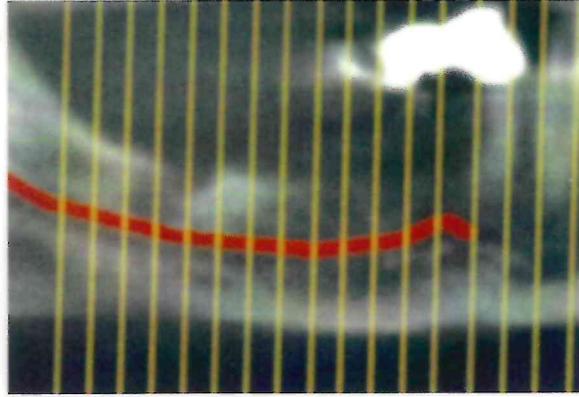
CT scan reveals that the inferior alveolar nerve was located high enough to present a considerable risk.
